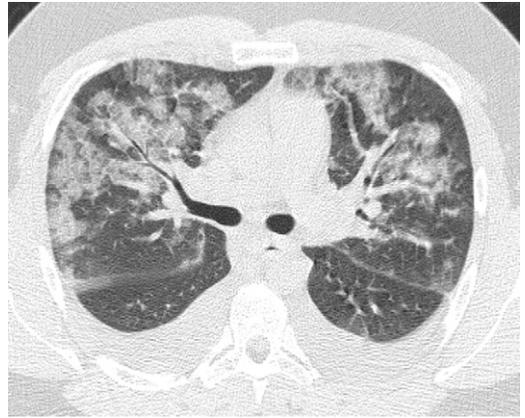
AEP. HRCT of the chest revealing bilateral consolidative and ground-glass opacities as well as pleural effusions in a 22-year-old man with AEP. The patient had begun smoking cigarettes 3 weeks before this evaluation of progressive dyspnea.
